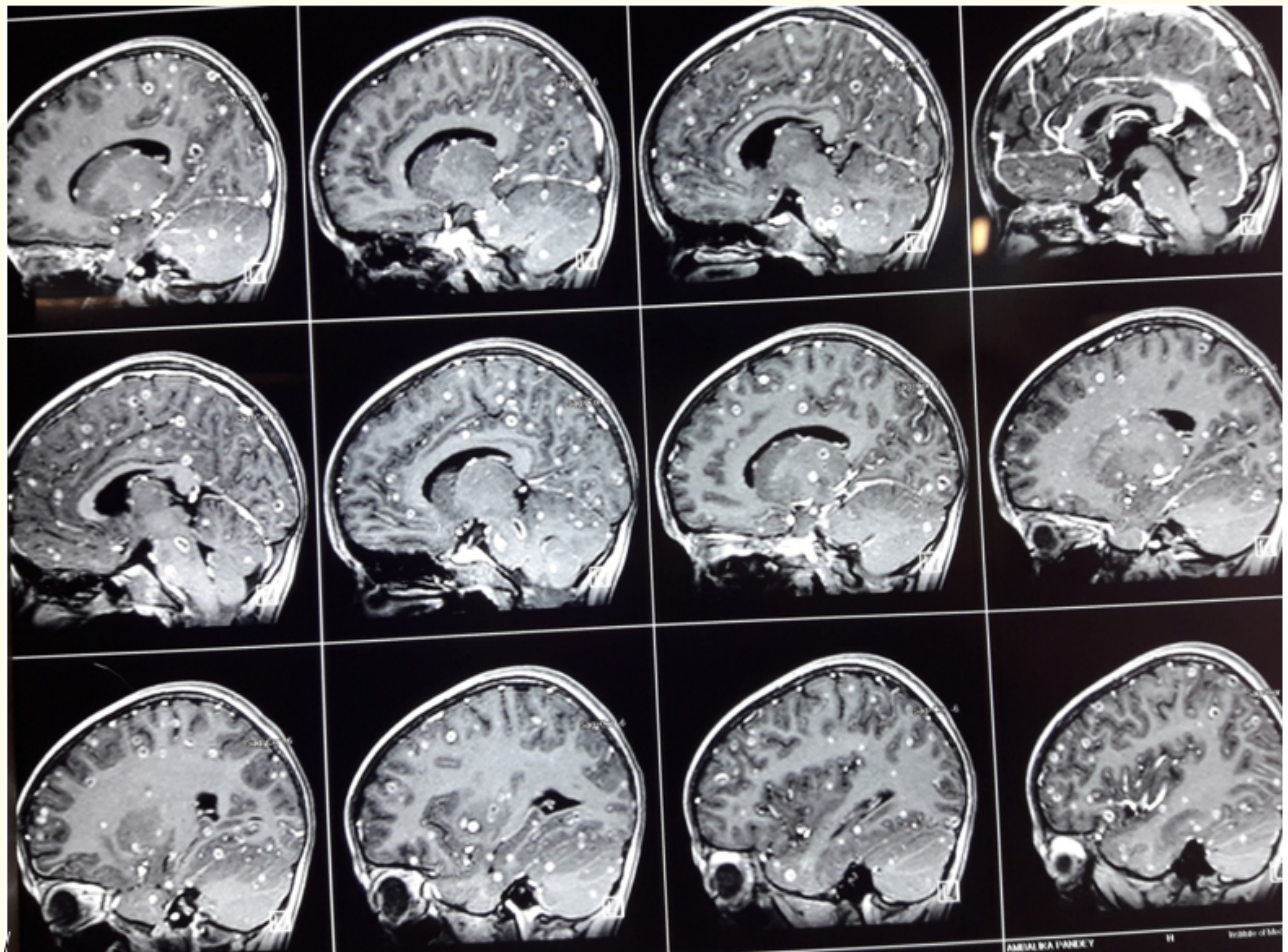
MRI of brain showing multiple cysticerci in sagittal section in different stages.
